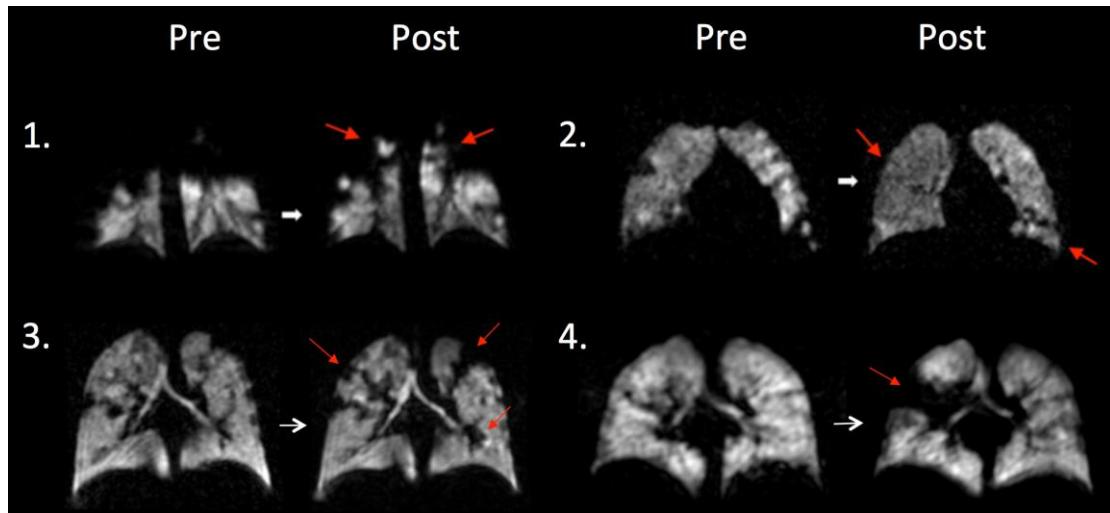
^{129}Xe ventilation MRI in four patients (1-4) pre and post CPET. Post exercise, patients 1 and 2 have significantly improved VDP and have areas of visual improvement in the distribution of ventilation. In contrast, patients 3 and 4 have a worsening in the distribution of ventilation post exercise, with new ventilation defects appearing. Red arrows depict areas of the lung, which have either improved ventilation post exercise, or depict a worsening in ventilation.
